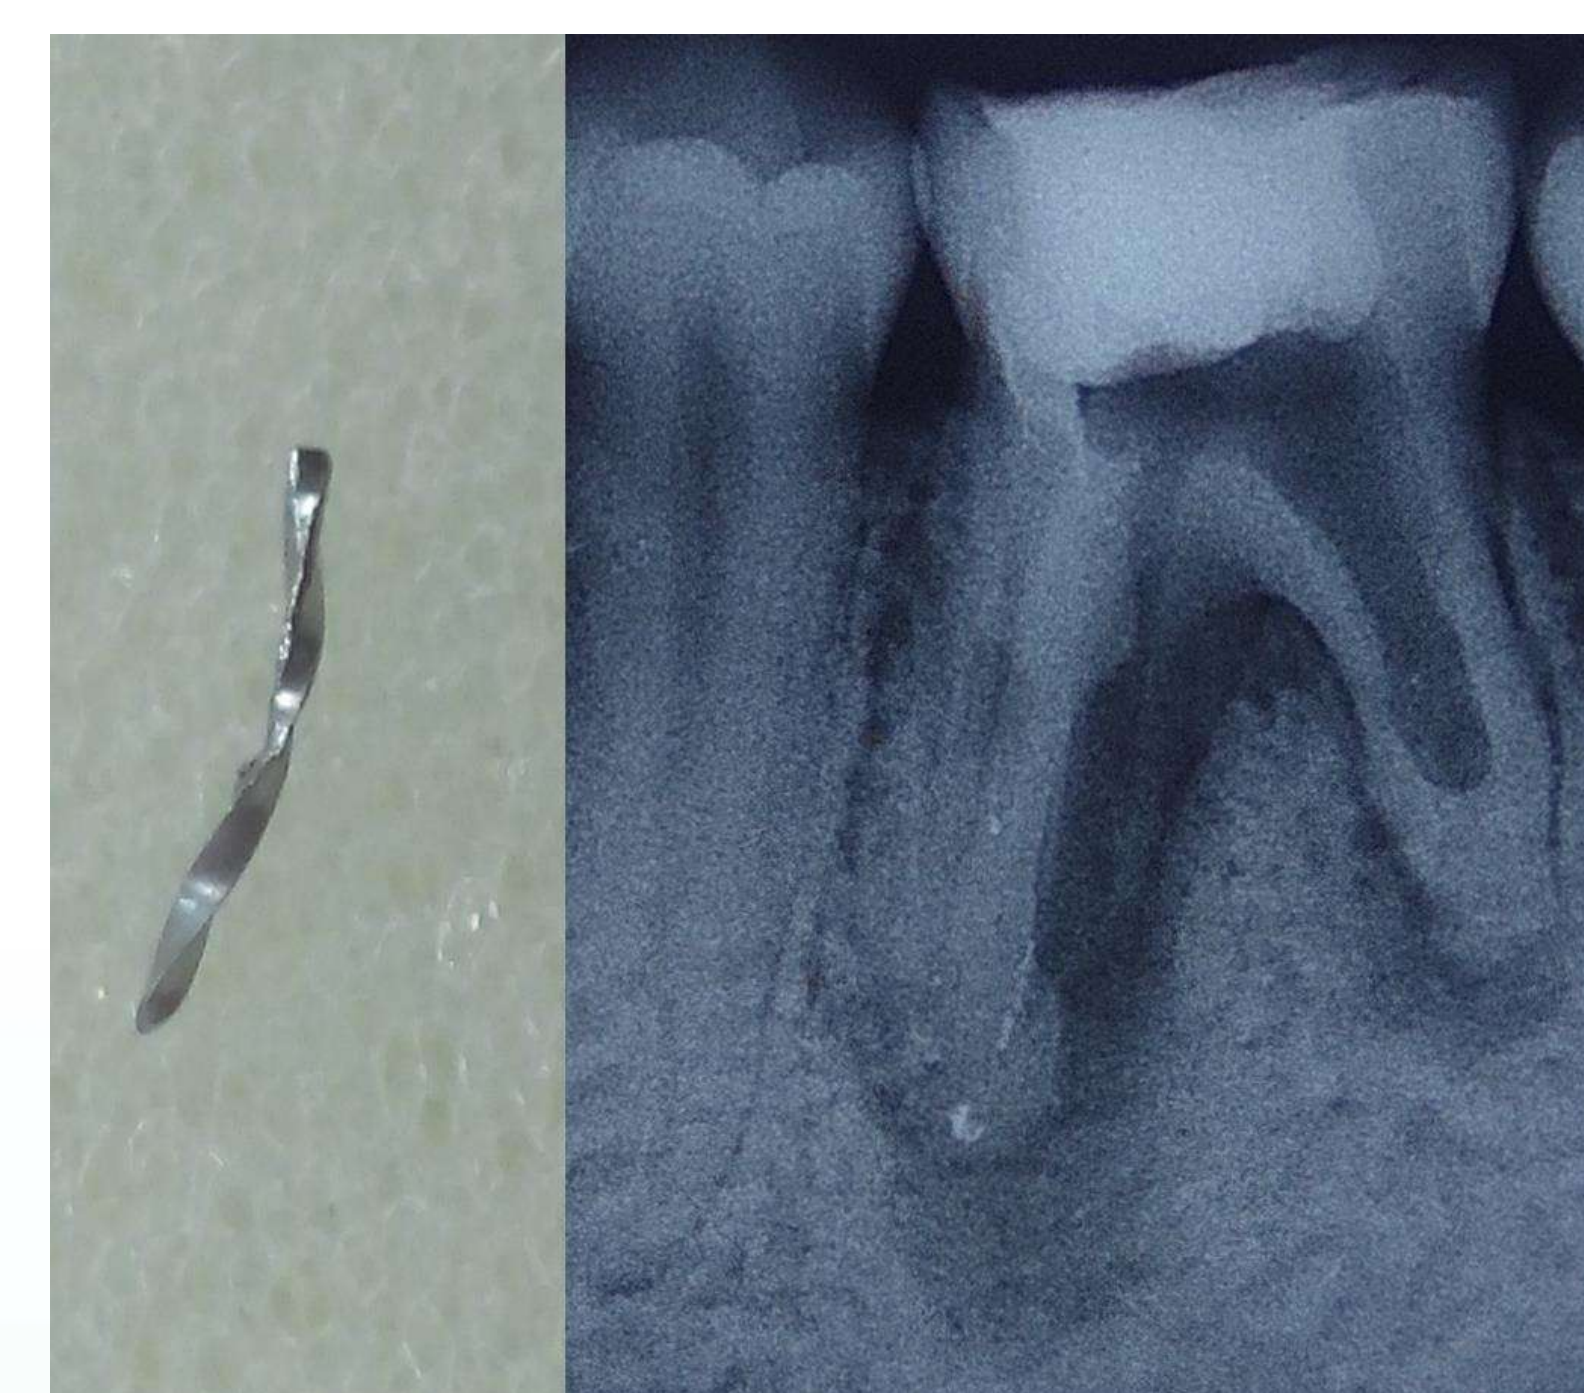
Radiograph after file removal
